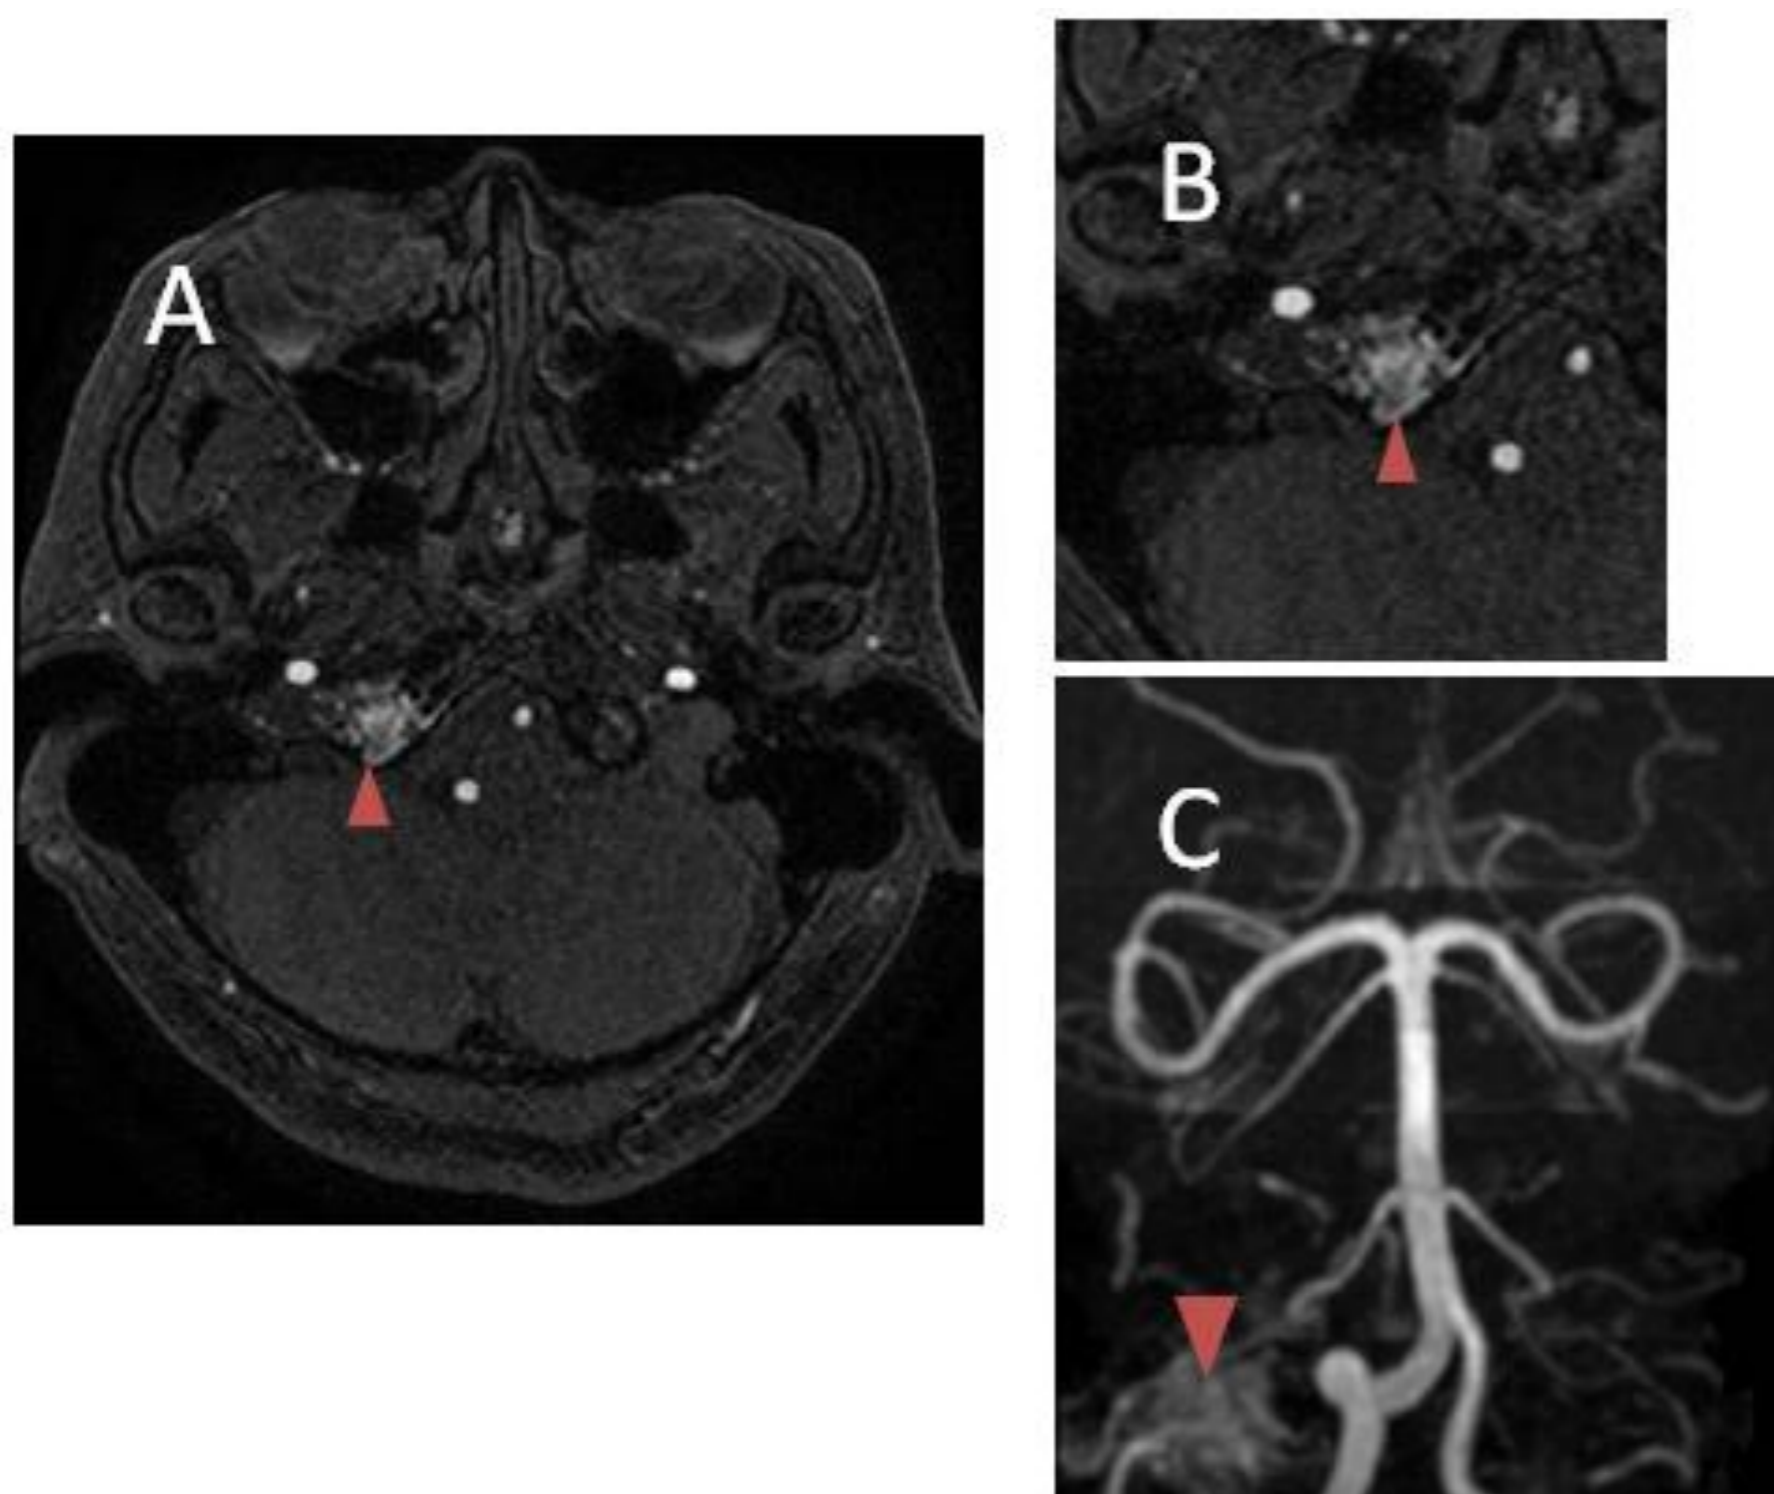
MRI / MRA axial (A), magnified view (B) and 3D reconstruction of MRA (C), showing the HCDAVF (red arrowhead)
